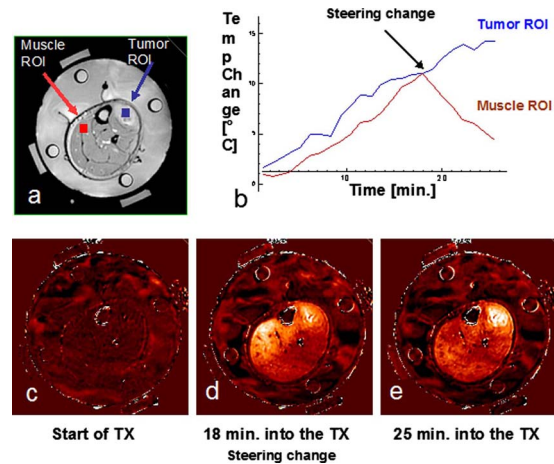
Summary of HT treatment: (a) Axial MRI image of the patient's lower extremity inside the MAPA applicator as seen in Fig. 2(a). (b) Temperature data as a function of time for two regions of interest: Muscle (normal tissue) ROI and tumor ROI. (c) Baseline temperature change map after 4 min of imaging without application of heat, temperatures in the leg are stable at about 36 °C. (d) Temperature rise image at approximately 18 min into treatment heating of tumor is visible but is less than undesirable heating of normal tissue on the upper left side of leg. (e) 25 min into treatment, after adjusting the antenna phases, heat is focused primarily in the tumor region creating a large differential heating of tumor.
